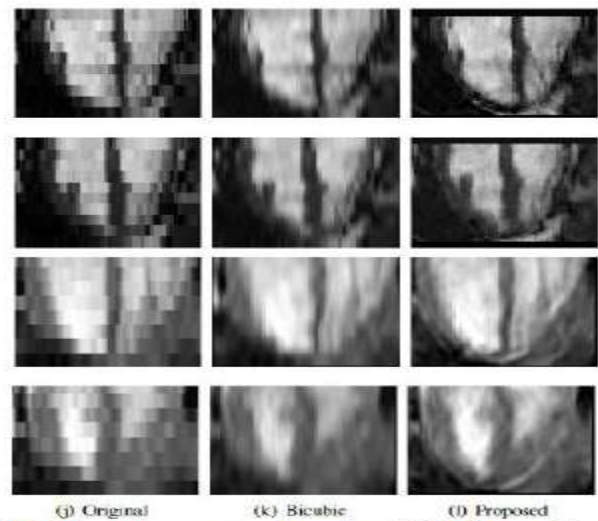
Example reconstruction of real MRI frames. First two rows: adult dataset. Bottom two rows: neonatal dataset.
